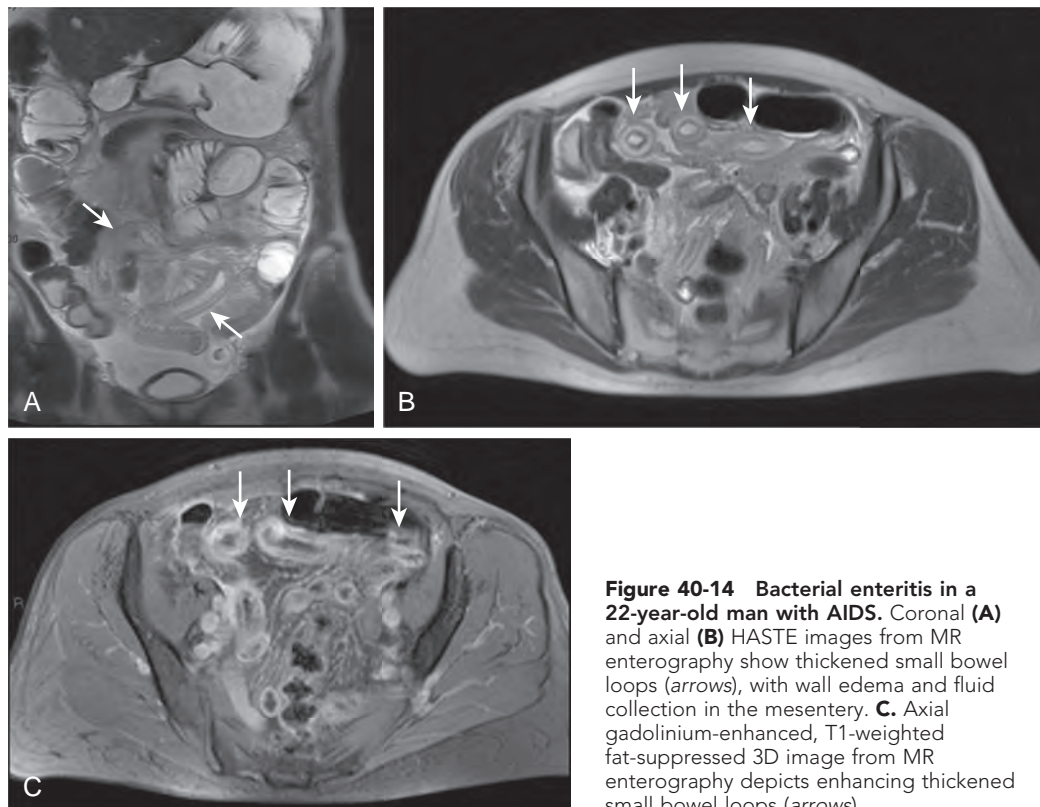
Bacterial enteritis in a 22-year-old man with AIDS. Coronal (A) and axial (B) HASTE images from MR enterography show thickened small bowel loops (arrows), with wall edema and fluid collection in the mesentery. C. Axial gadolinium-enhanced, T1-weighted fat-suppressed 3D image from MR enterography depicts enhancing thickened small bowel loops (arrows).
